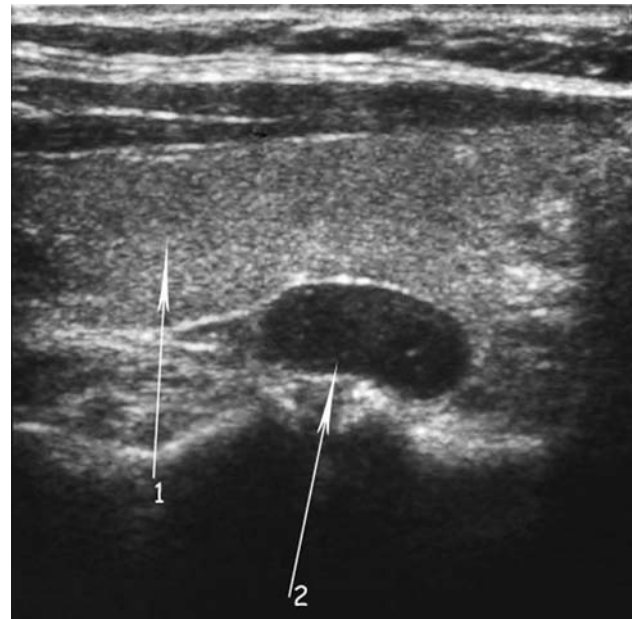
Ultrasonography. Arrow 1: right thyroid lobe. Arrow 2: right superior parathyroid adenoma posterior to the two superior thirds of the thyroid lobe: position 1
